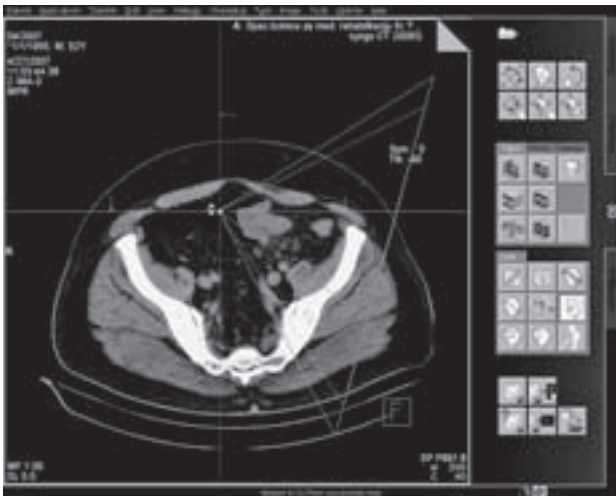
HRCT scan of abdomen in the axial plane revealed the above mentioned cancer of the sigmoid colon. Virtual endocamera view directed towards the tumor.
